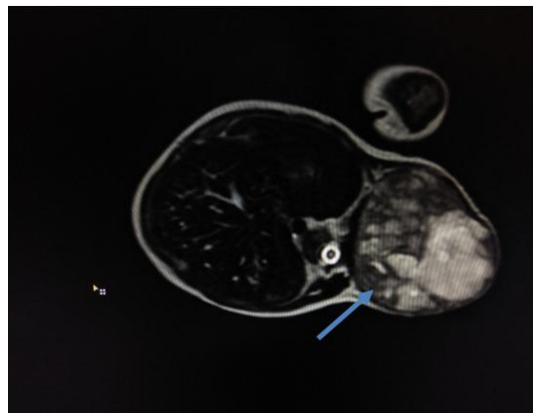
MRI showing a paravertebral lesion
